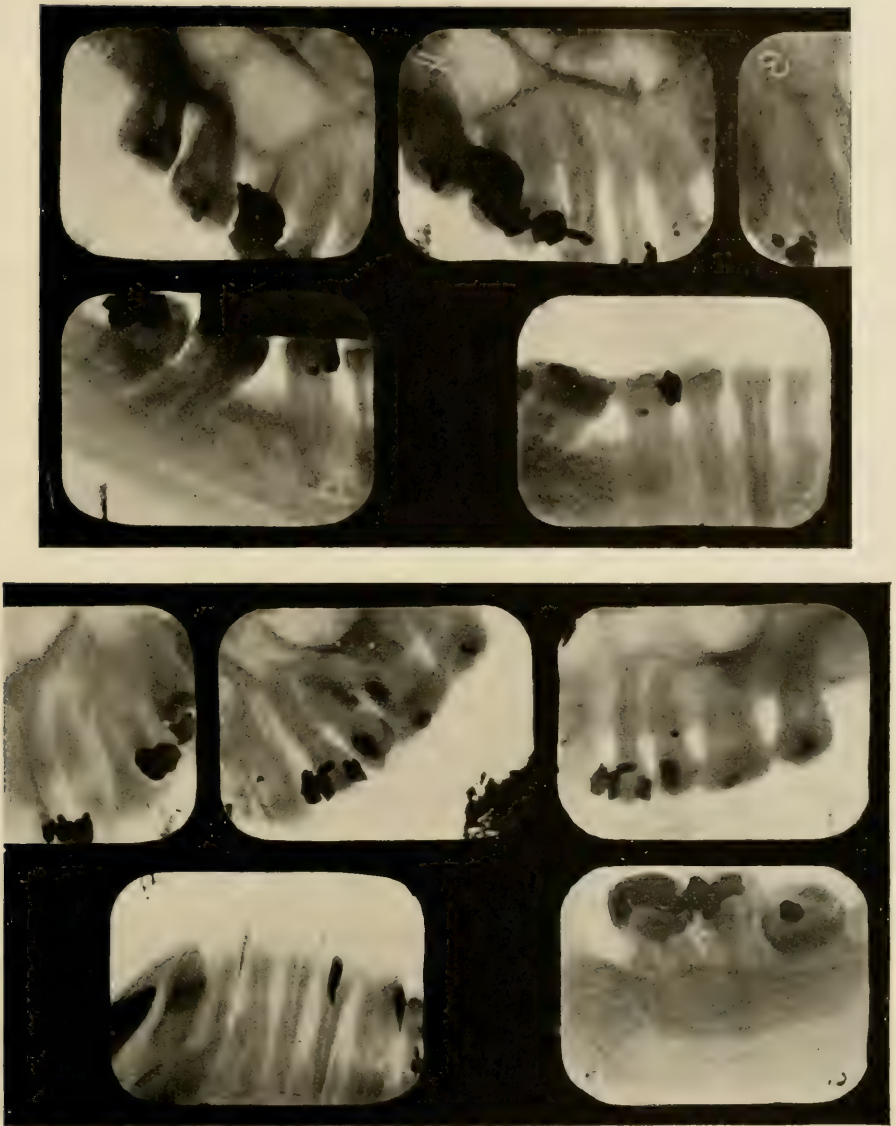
"Horrible Example." A number of radiographs intended to be a radiographic examination of all the teeth in the mouth. In reality it is a radiographic examination of only a very few teeth.
